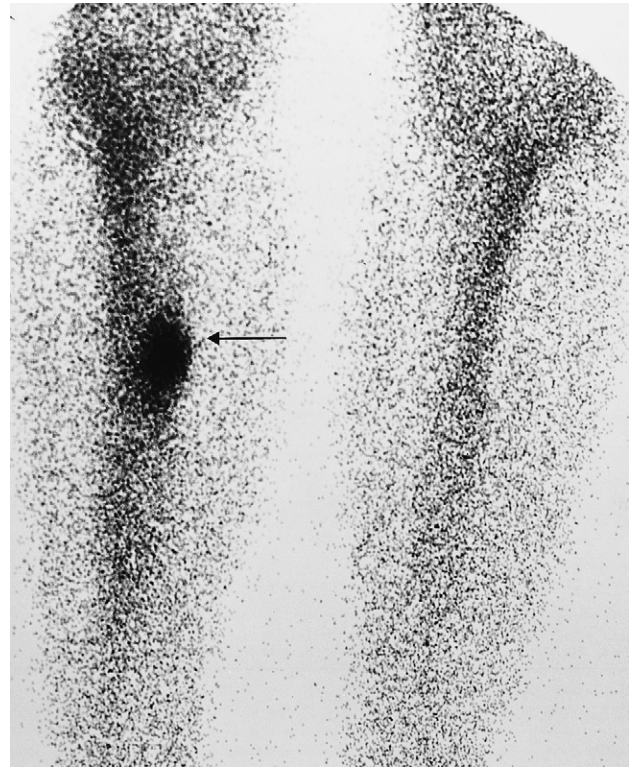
Stress fracture. Radionuclide bone scan showing increased uptake in the tibia (arrow) of this athlete with pain in the leg. The radiographs at the time of the scan were normal.
